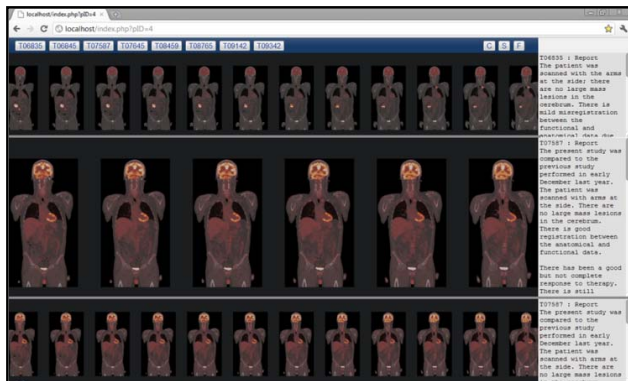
TAGIGEN viewer showing three follow-up scans (from a total of eight) of a patient study. The coronal fused PET-CT view is displayed.
